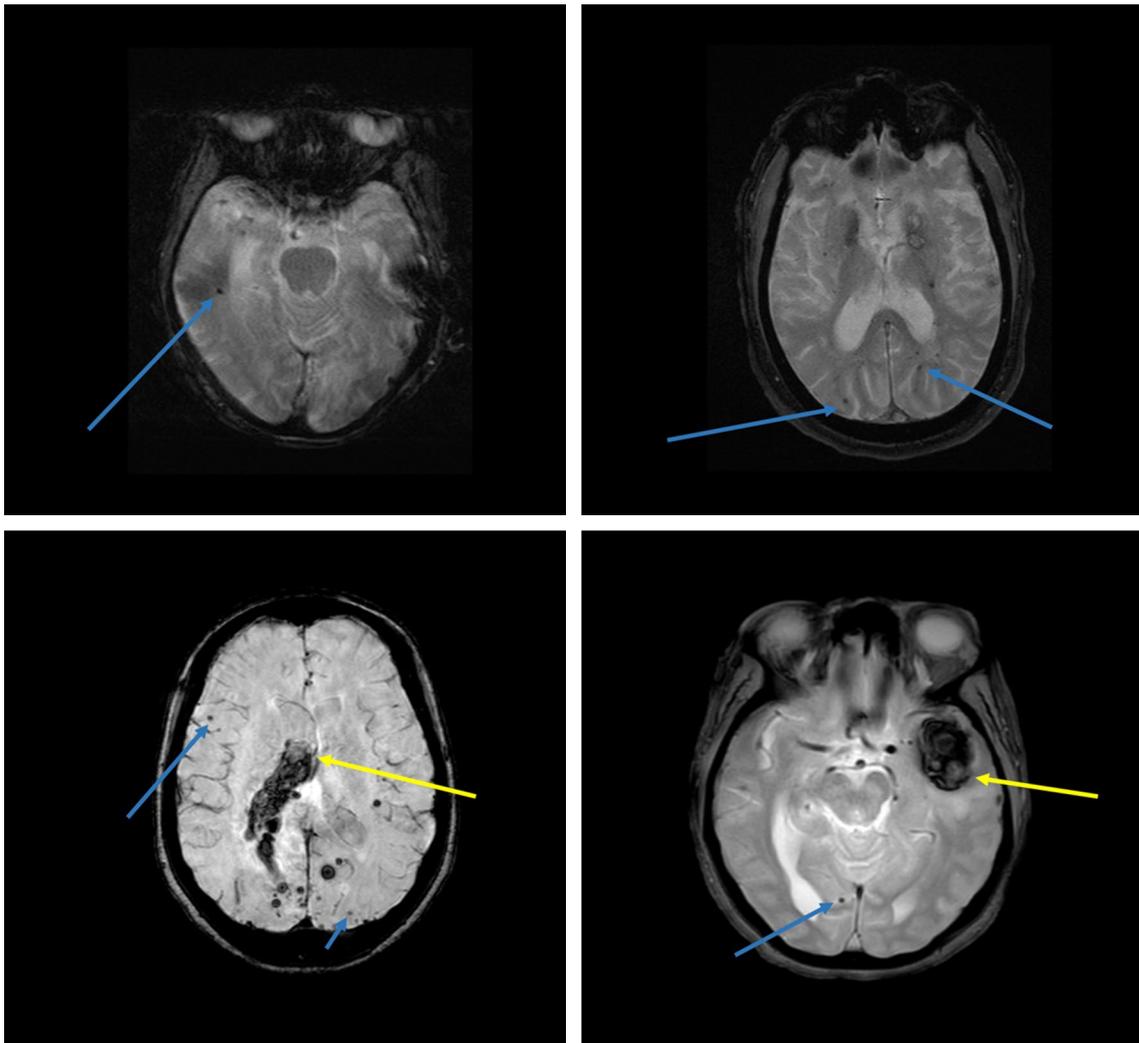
Top: MRI with GRE (gradient echo) sequence; bottom: SWI (susceptibility-weighted imaging); CAA patients with: blue arrows—cerebral microbleeds (CMBs), yellow arrows—CAA-related intracerebral hemorrhage
